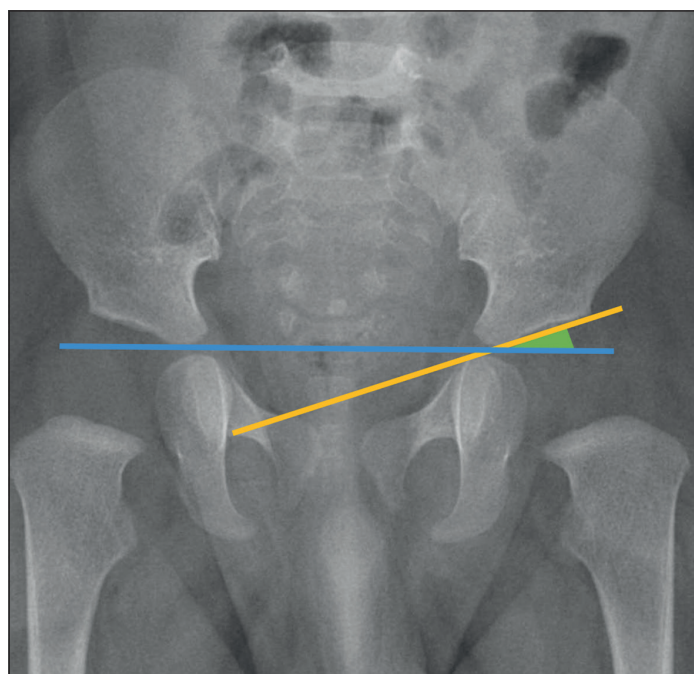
Measurement of the acetabular index on an anteroposterior pelvic radiograph. Hilgenreiner's line (blue) is a horizontal line connecting the triradiate cartilages. The acetabular roof line (yellow) extends from the lateral edge of the acetabular roof to the most medial point where it intersects Hilgenreiner's line. The acetabular index (green area) corresponds to the angle formed between both lines and reflects the slope of the acetabular roof.
